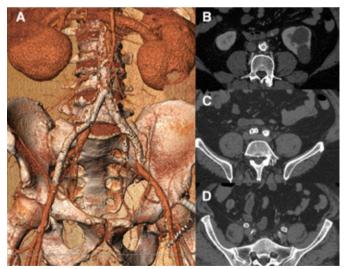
Post-operative CTA of the 4th patient treated with the CERAB technique. Right external iliac artery stenting was accomplished to treat a residual stenosis; Panel A, 3D reconstruction and B-D, axial views.
